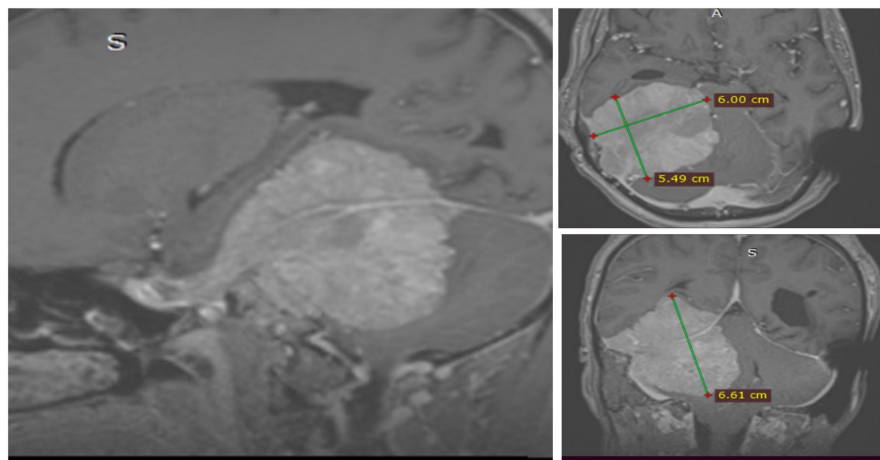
Brain MRI showing a mass measuring 60 × 54 millimeters.
